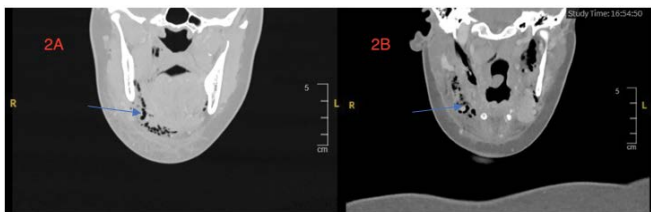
A & B Coronal view CT scan of the neck showing surgical emphysema at the level of right submandibular space
